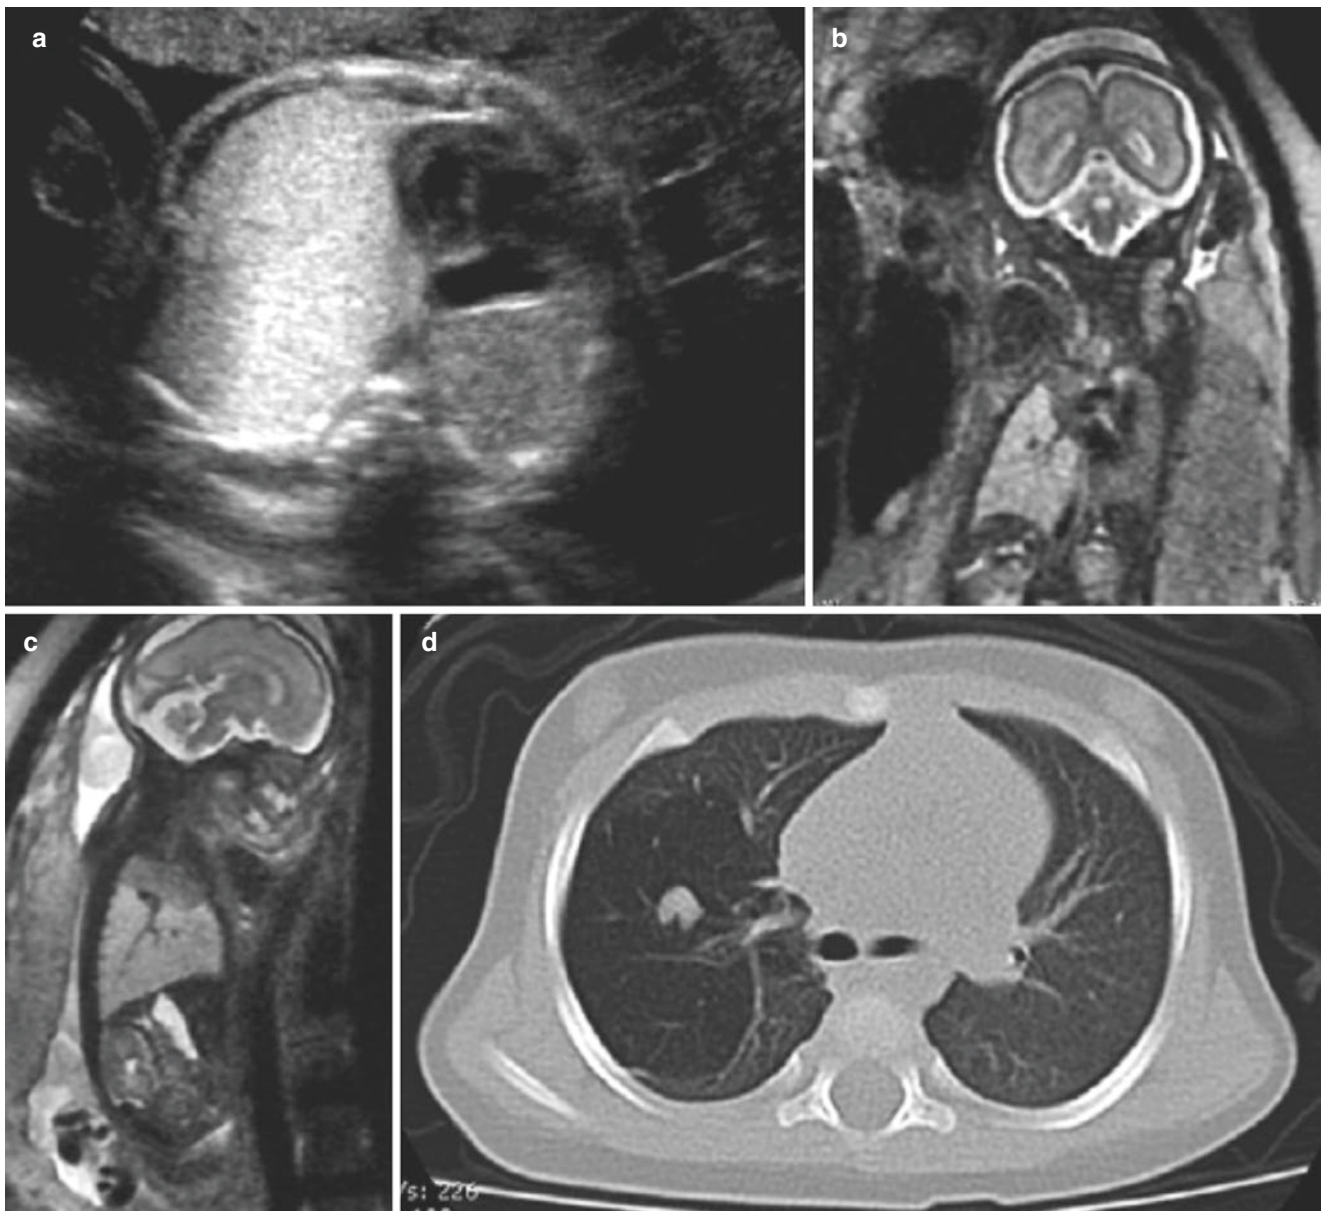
Congenital lobar overinflation (CLO). (a) Axial US at 27 weeks' gestation demonstrates a large echogenic mass in the right hemithorax deviating the heart to the left. No systemic feeding vessel was identified. (b) Coronal and (c) sagittal SSFSE T2w MR image at
